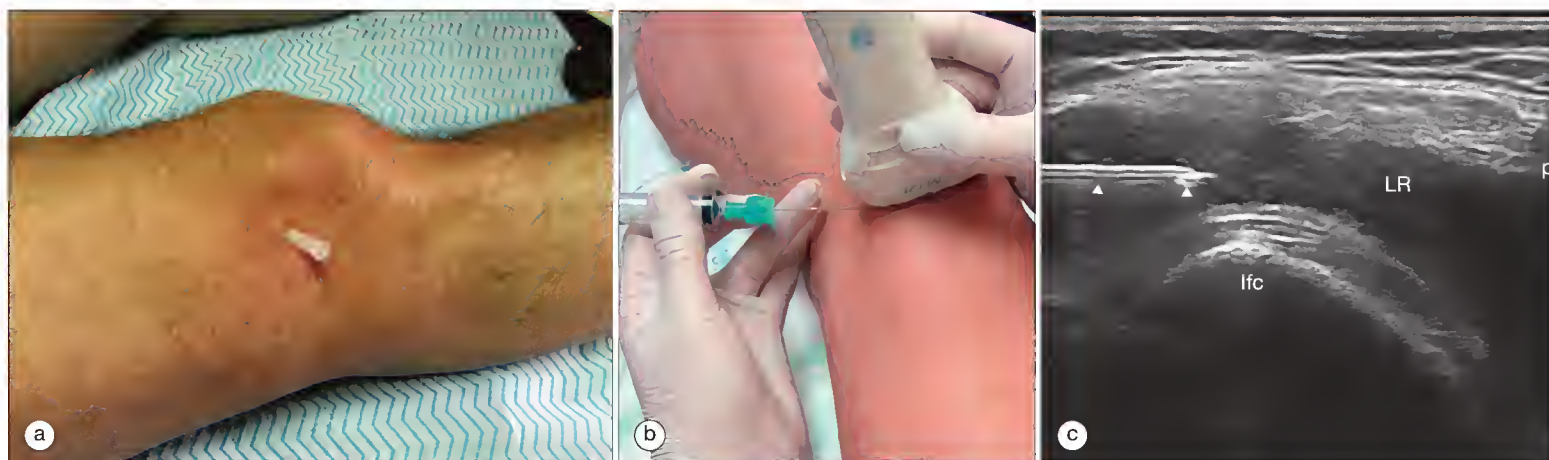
(a) Knee injection, lateral approach, right knee osteoarthritis. (b) Ultrasound-guided direct method of injection into the knee. The needle is inserted adjacent to the transducer and directed to the lateral recess of the knee. (c) Ultrasound-guided injection into the lateral recess of the knee. The needle has a hyperechoic appearance (arrowheads) inside the lateral recess, which is distended by synovitis. lfc, lateral femoral condyle; LR, lateral recess; p, patella.
